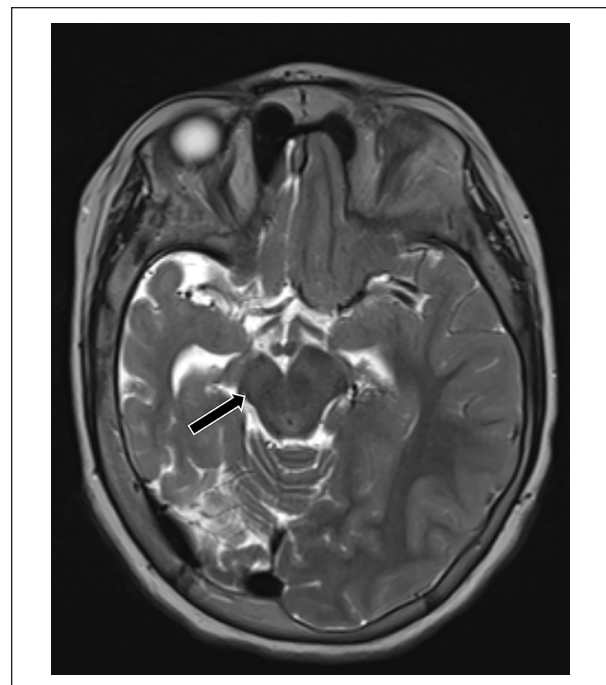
Axial T2 sequence of MRI showing a mesencephalon atrophy (Black arrow).
